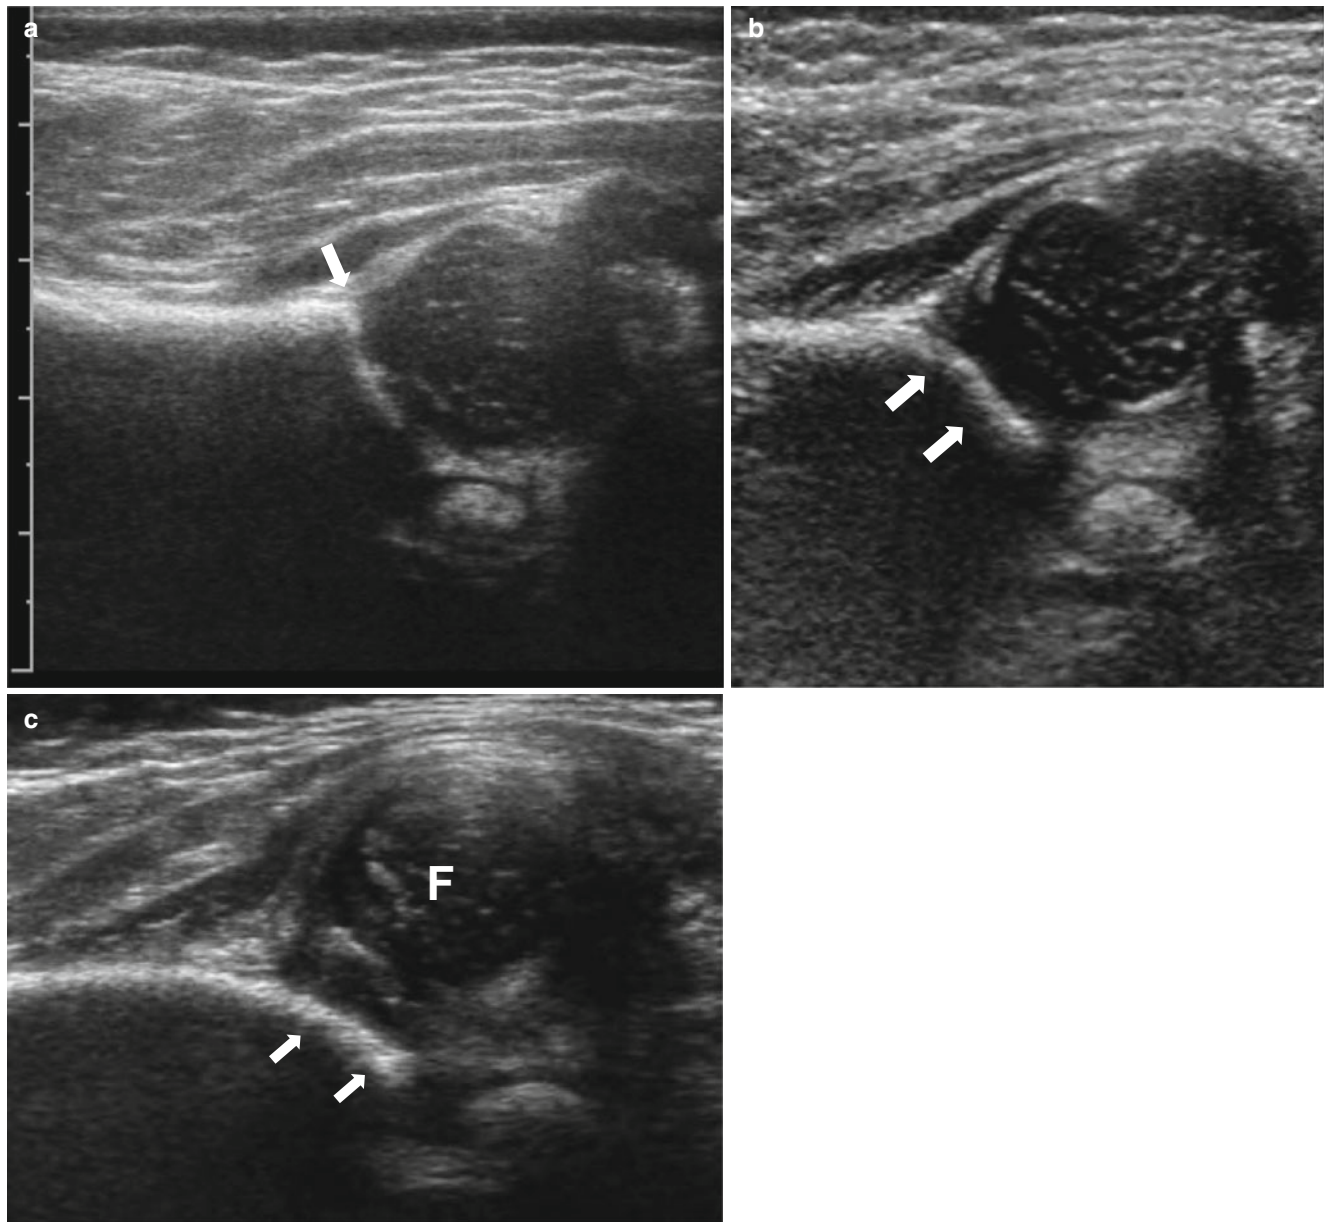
Ultrasonographic spectrum of developmental dysplasia of the hip. (a) Normal hip. The superior acetabular rim is angular (*arrow*). (b) Lateral edge of the bony acetabulum shows rounded appearance
